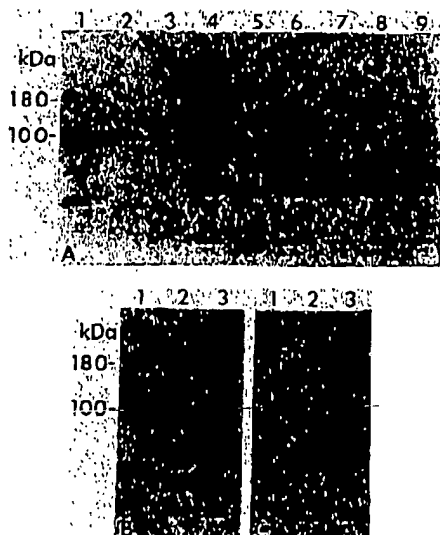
Detection of PSMA in serum. (a) Western blot, using 7E11-C5.3, of 25 µg of an LNCaP membrane extract (lane 1) and normal prostate (lane 2) membrane extracts, 100 µg of normal seminal plasma (lane 3), 400 µg of spiked pooled stage D2 serum (lane 4), 20 µg of affinity-purified stage D2 serum (lane 5), 400 µg of pooled serum from stage D2 CaP (lane 6), BPH (lane 7), normal man (lane 8) and normal women (lane 9). (b) Western blot of 25 µg of an LNCaP membrane extract (lane 1), 400 µg of pooled D2 serum (lane 2) and 800 µg of pooled D2 serum blotted with MAb 7E11-C5.3. (c) The identical blot probed with MAb 7E11-C5.2 plus N1.19 PSMA peptide. No PSMA was detected by affinity chromatography of the pooled D2 serum (a, lane 5), and whereas bands are present in the pooled sera, the same bands are present in the pooled normal male and female serum. The bands in the LNCaP extract were eliminated by competition with the N1.19 peptide whereas the bands in the pooled serum remained.
